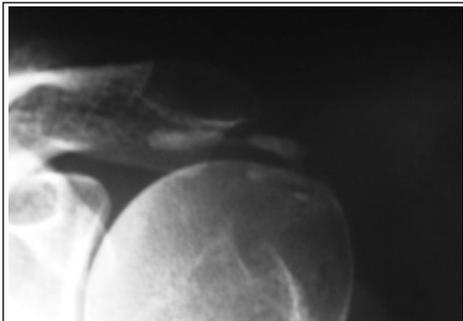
Preoperative X-ray showing Gärtner stage I calcium deposits located in the supraspinatus tendon.
